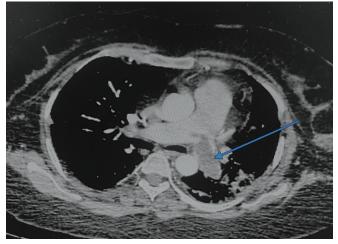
Contrast-enhanced computed tomography of thorax showing thrombus obstructing left main pulmonary artery
